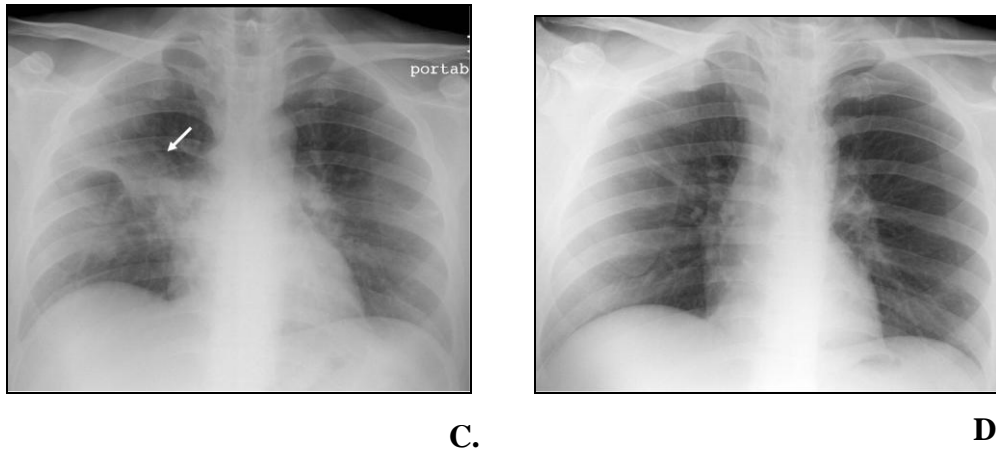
(A) Initial chest PA film shows a patchy area of consolidation at right middle lung zone (arrow), consistent with pneumonia. (B) 7 days later, chest film reveals progressive alveolar infiltrates to right upper lung zone (arrow) and left perihilar region (arrowhead). (C) Chest X-ray obtained 9 days later shows regression of the infiltration at left perihilum and right upper lung zone (arrow). (D) After 19 days, chest film shows clear lung before discharge.
